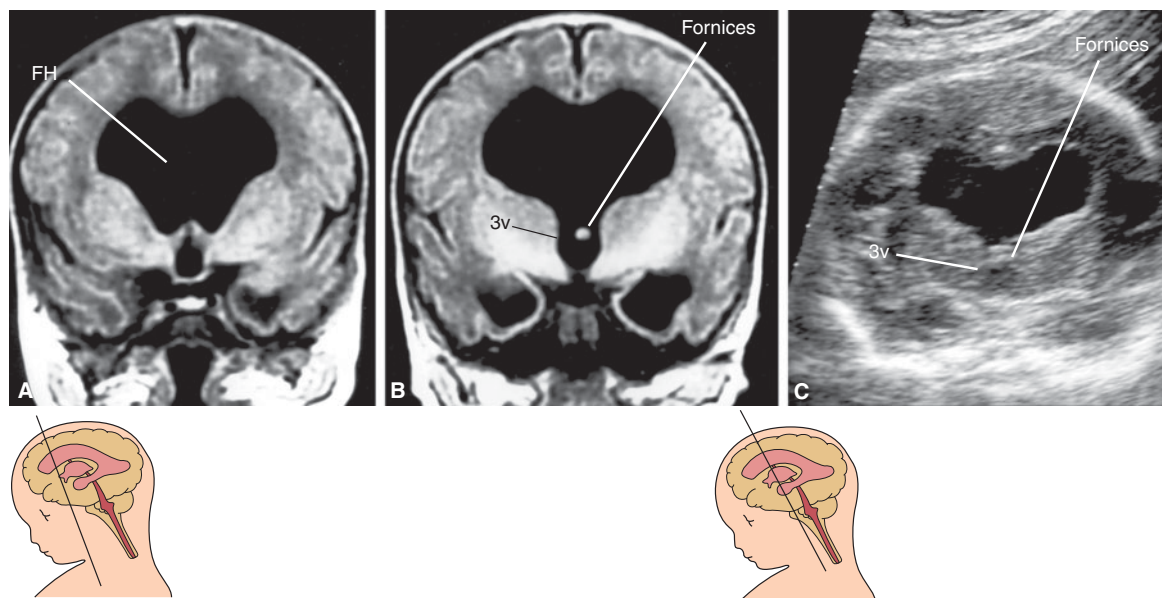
The appearance of a well-developed frontal cortex and ventricular system associated with obstructive dilation favors the diagnosis of holotelencephaly. The fornices (arrow) are fused and form a thick fascicle running in the floor of the ventricular cavity. (Reproduced, with permission, from Pilu G, Ambrosetto P, Sandri F, et al. Intraventricular fused fornices: A specific sign of fetal lobar holoprosencephaly. *Ultrasound Obstet Gynecol.* 1994;4[1]:65–67.)
